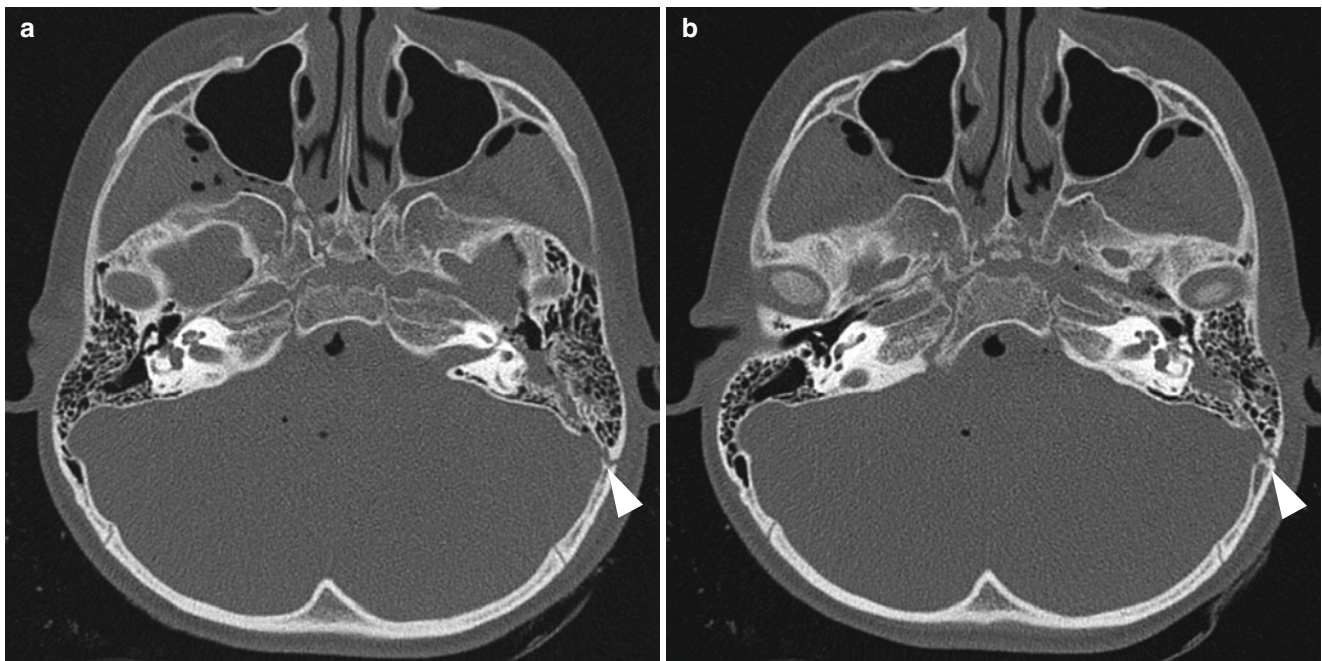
Longitudinal temporal bone fracture with bloody otorrhea and ipsilateral facial nerve palsy. (a, b) Thin-section temporal bone CT scans show a longitudinal fracture through the middle ear cavity and mastoid antrum and air cells (*arrowheads* in a and b). The middle ear
